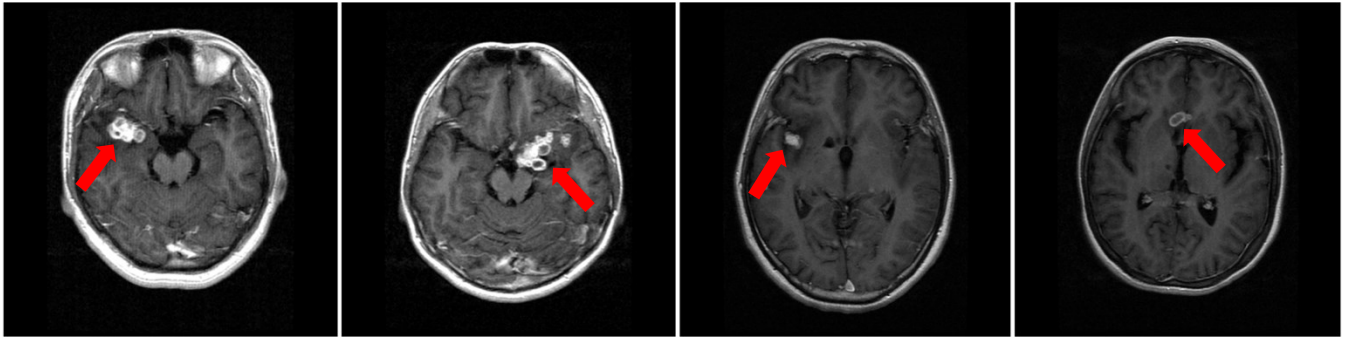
The varied radiological appearances of tuberculosis in MRI images.
